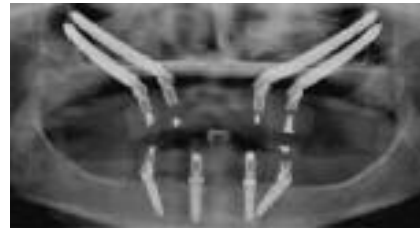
Postoperative orthopantomography of an All-on-4 Extra-Maxilla rehabilitated patient with the immediate provisional prosthesis in place.
